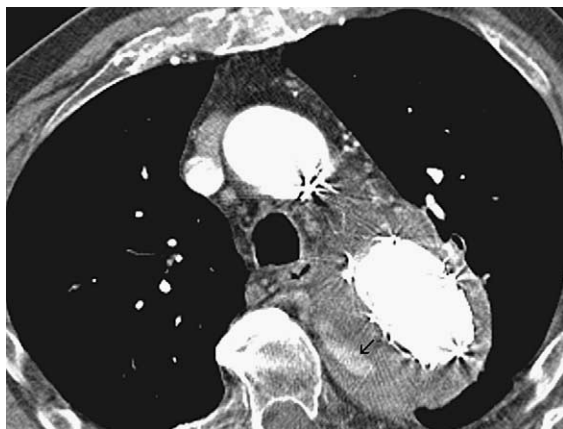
Thoracic CT (August 2003) shows a perfused false lumen of a type B dissection (arrow) and soft tissue surrounding the aortic stent-graft with inflammatory changes in the mediastinum.
